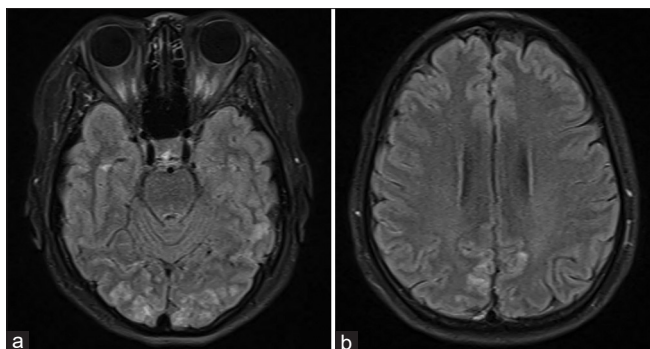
T2W1/T2 FLAIR MRI showing bilateral occipital lobe (a) and posterior cingulate gyrus (b) hyperintensities, which are nearly symmetrical, consistent with Posterior reversible encephalopathy syndrome
